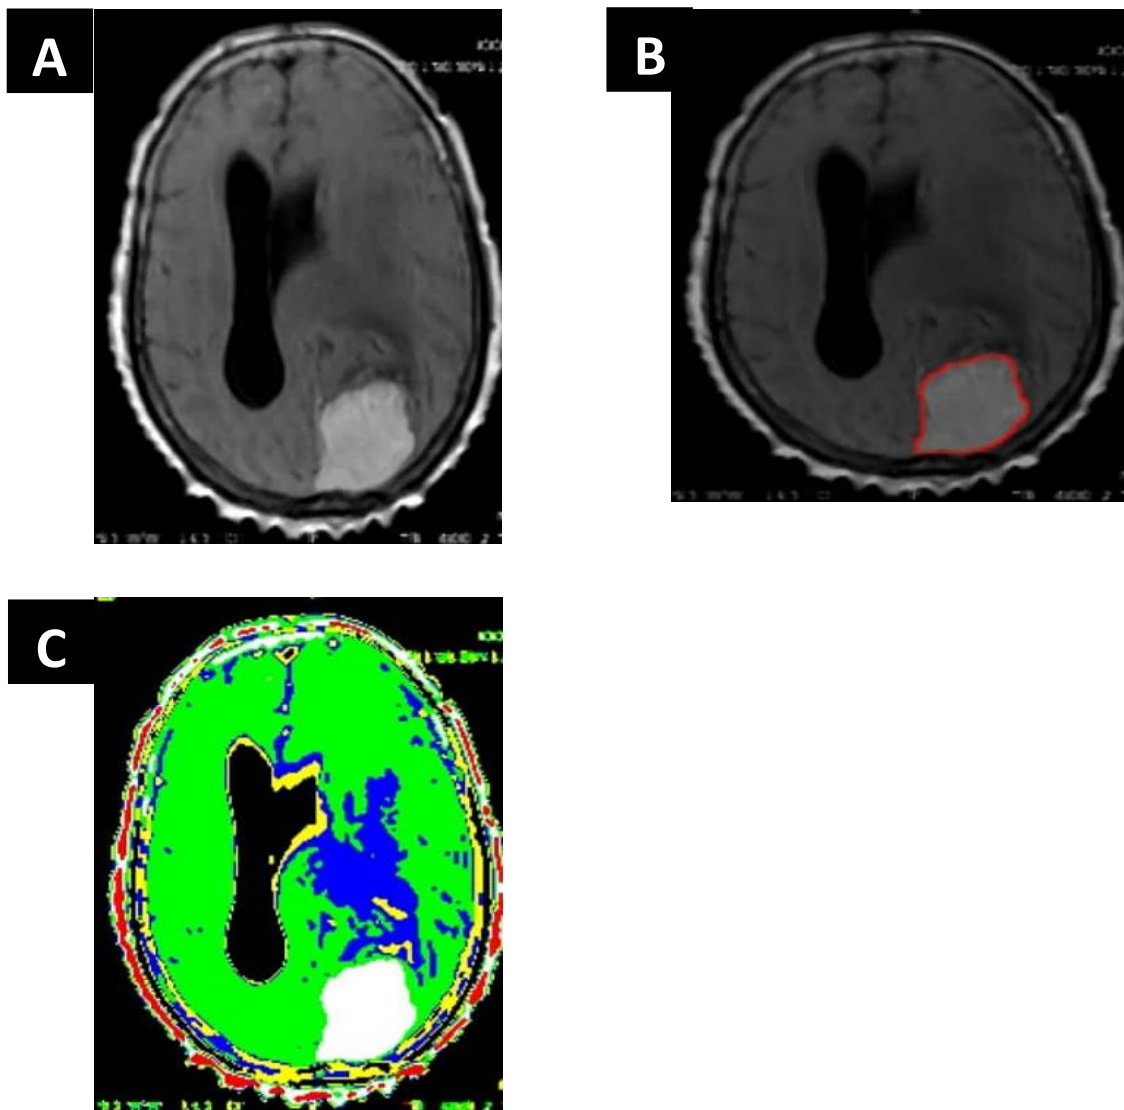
Demonstrates MR image (A) the original MR image with contrast demonstrate the brain tumor. (B) Shows the lesion (brain tumor) drawn using
